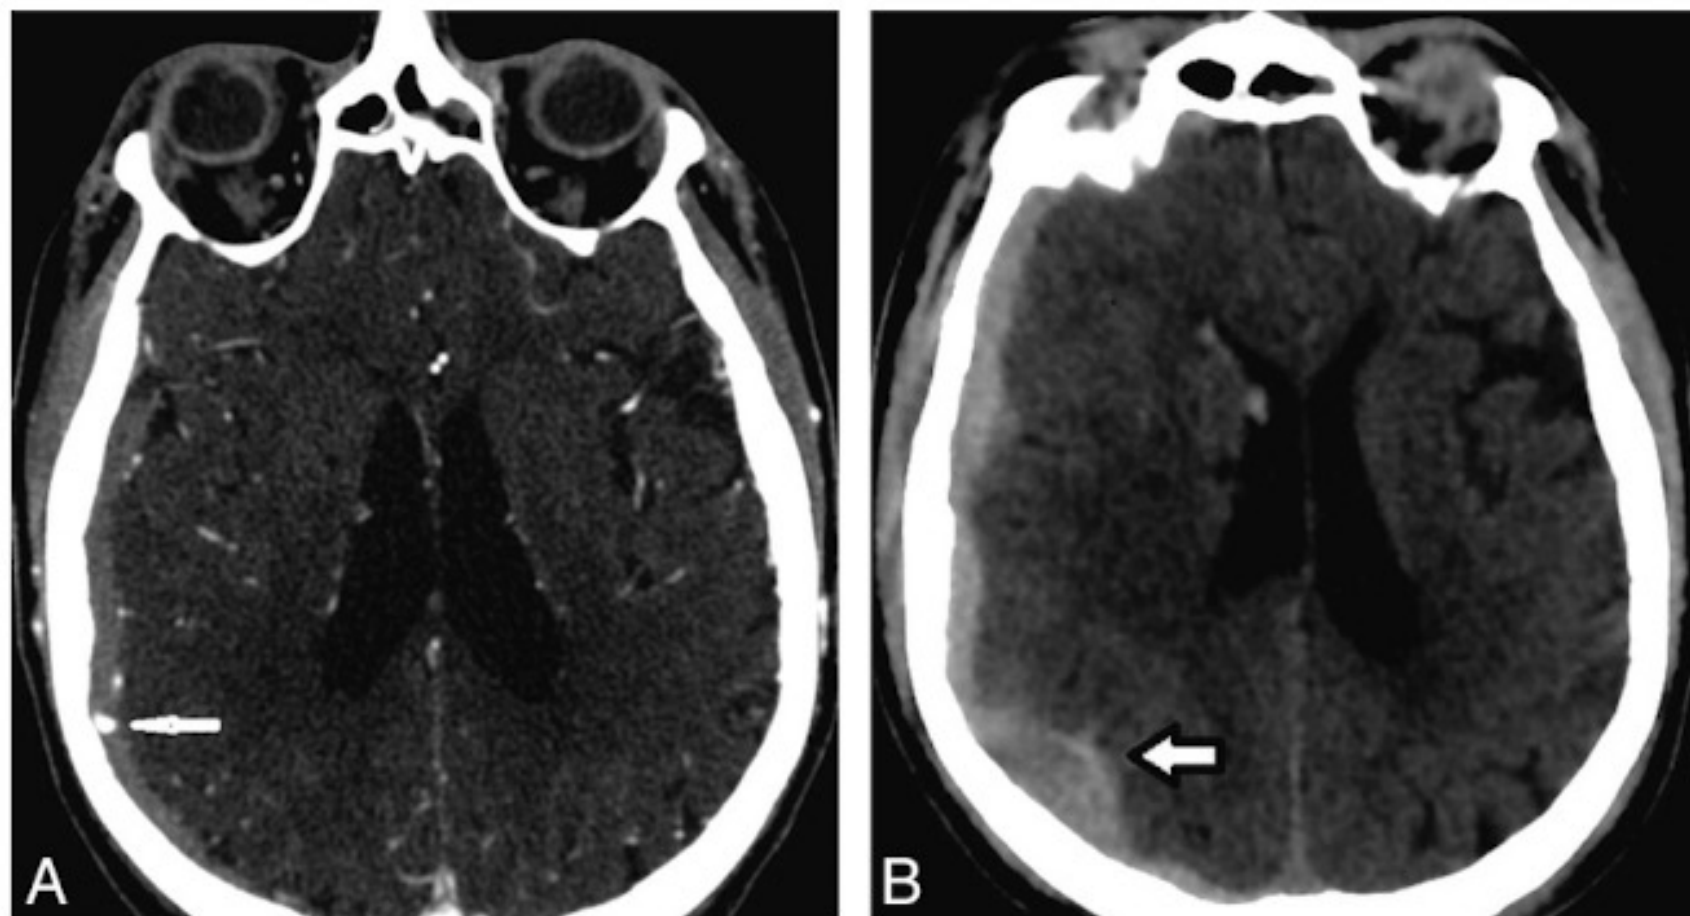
CT images of a 75-year-old man with blunt craniocervical trauma related to a motor vehicle crash. *A*, Axial source image from the CTA of the head in the emergency department demonstrates contrast extravasation (*arrow*) in the right hemispheric aSDH. *B*, Follow-up axial NCCT of the head at approximately the same level (obtained 4 hours later) demonstrates an increase of $>20\%$ of the aSDH thickness (*arrow*).
